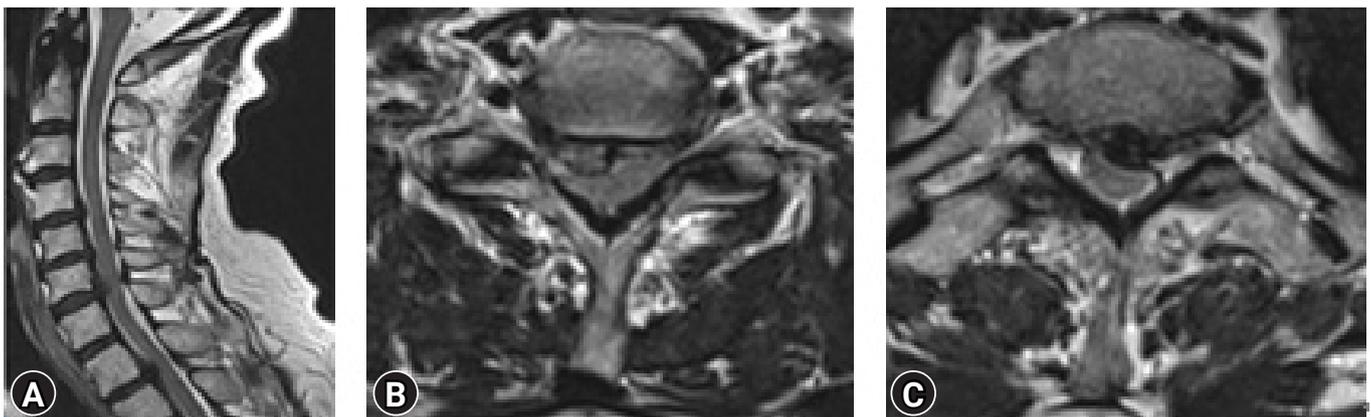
(A) Preoperative, sagittal T2 magnetic resonance imaging (MRI) of C6-7 and T1-2 disc herniation with signs of cord compression. (B) A preoperative, axial T2 MRI shows right disc herniation at C6-7. (C) A preoperative axial T2 MRI revealing central disc herniation at T1-2 is shown.
